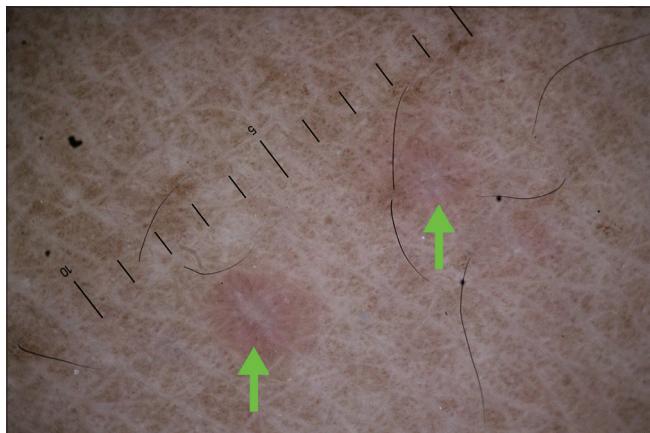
Polarised light dermoscopy after application of ultrasound gel of early classical lichen planus showing background of diffuse erythema with radial Wickham striae (green arrow) (original magnification, $\times 10$)
